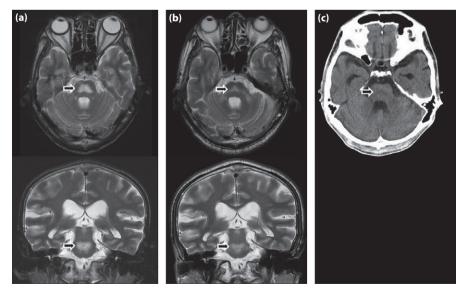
Cranial magnetic resonance imaging (a) on hospital day 7, (b) 5 months after hospitalization (both T2-weighted images; upper image: transaxial view, lower image: coronal view) and (c) cranial computed tomography on admission.
